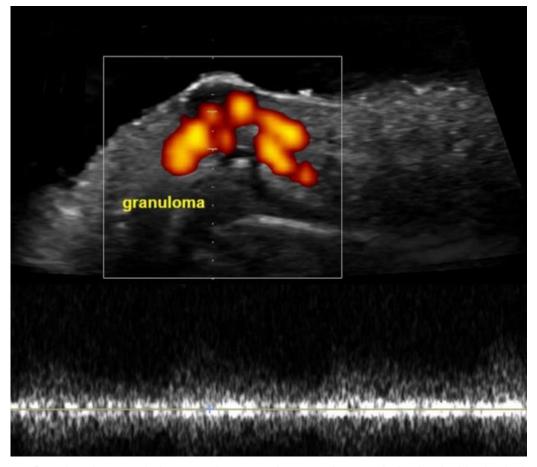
Power Doppler ultrasound shows an important increase in vascularisation inside the lesion, the spectral curve corresponds to an arterial low-resistant vessel.
